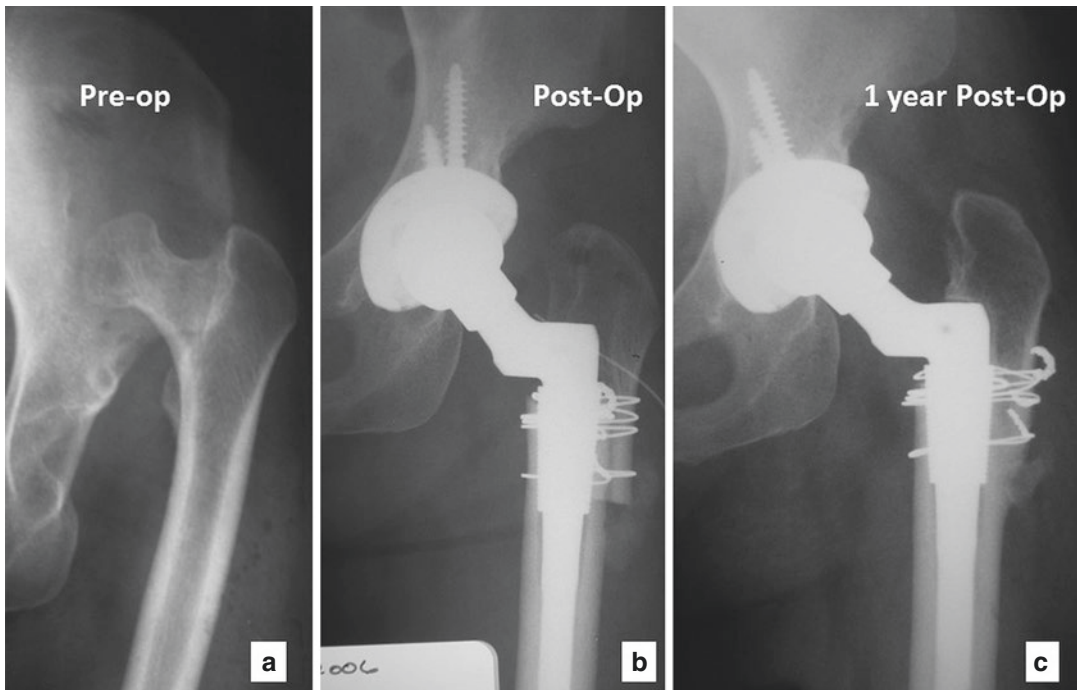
Radiographs of a Crowe 4 DDH case. (a) Pre-op, (b) Immediate post-op, and (c) 1-year post-op with excellent remodeling
